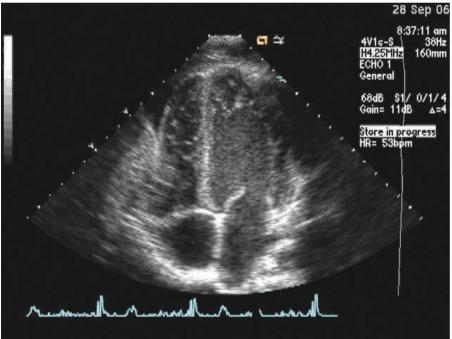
Contrast echocardiography demonstrating trabeculation of left ventricular noncompaction.
